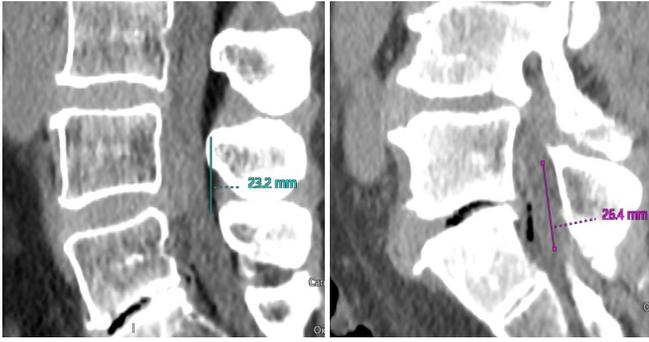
CT, sagittal view. The sequestered disc herniations.
